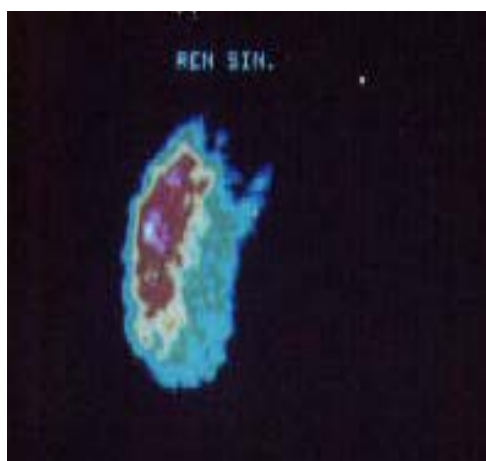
Static renal scintigraphy with ^{99m}Tc -DMSA (dimercaptosuccinic acid). On a scintigram only the left kidney is defined. Accumulation of ^{99m}Tc -DMSA by a left kidney is intensive enough; its distribution is diffusively non-homogenous, in the top pole is detected a defect of radionuclide accumulation. Focal lesion of the top pole of a left kidney. The right kidney is not detected
